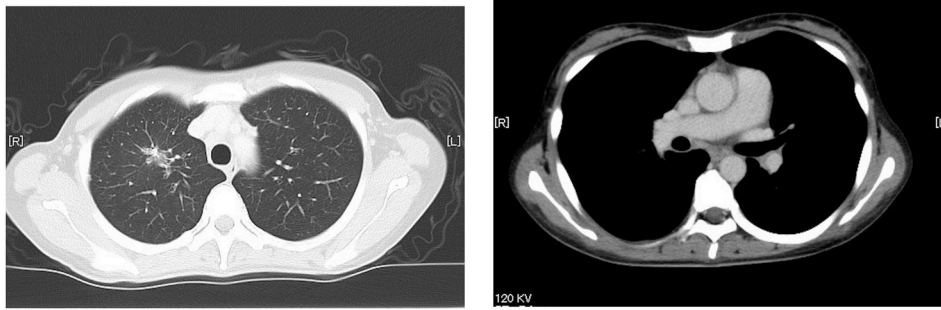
Computed tomography shows remarkable remission of right upper nodule (A) and mediastinal lymphadenopathy (B) after osimertinib induction.
